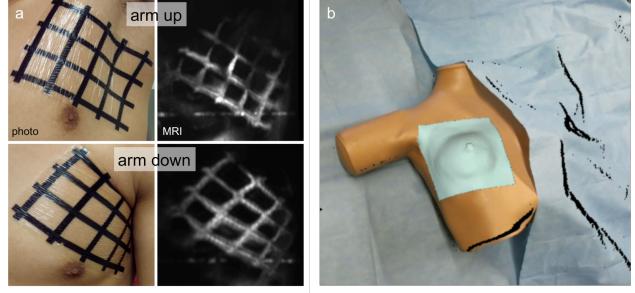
Possible alternative registration methods. a) We are developing temporary skin markings that are visible both optically and on MR images and can be printed in arbitrary shapes, which can track deformation with arm position and may aid in improving the registration when combined with a deformable model of the breast. b) Markerless breast tracking using an RGBD camera (Microsoft Kinect V2) can be used to overlay a breast model obtained from previously acquired volumetric images onto a patient mannequin.
